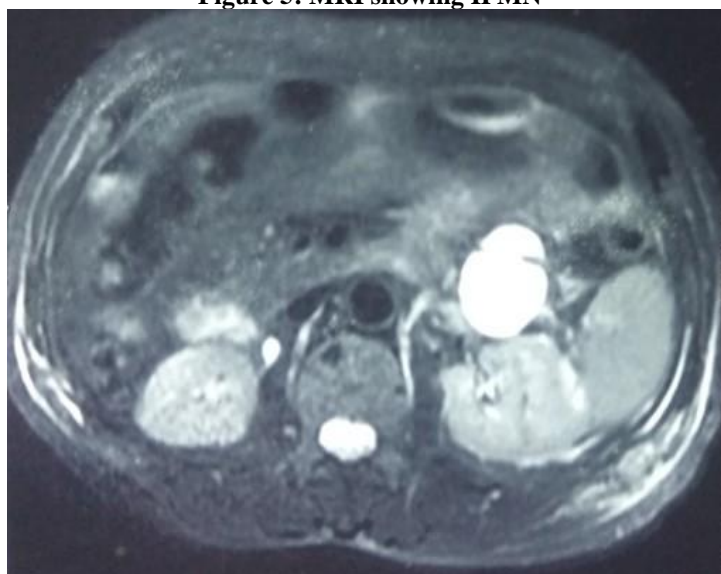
MRI showing IPMN
